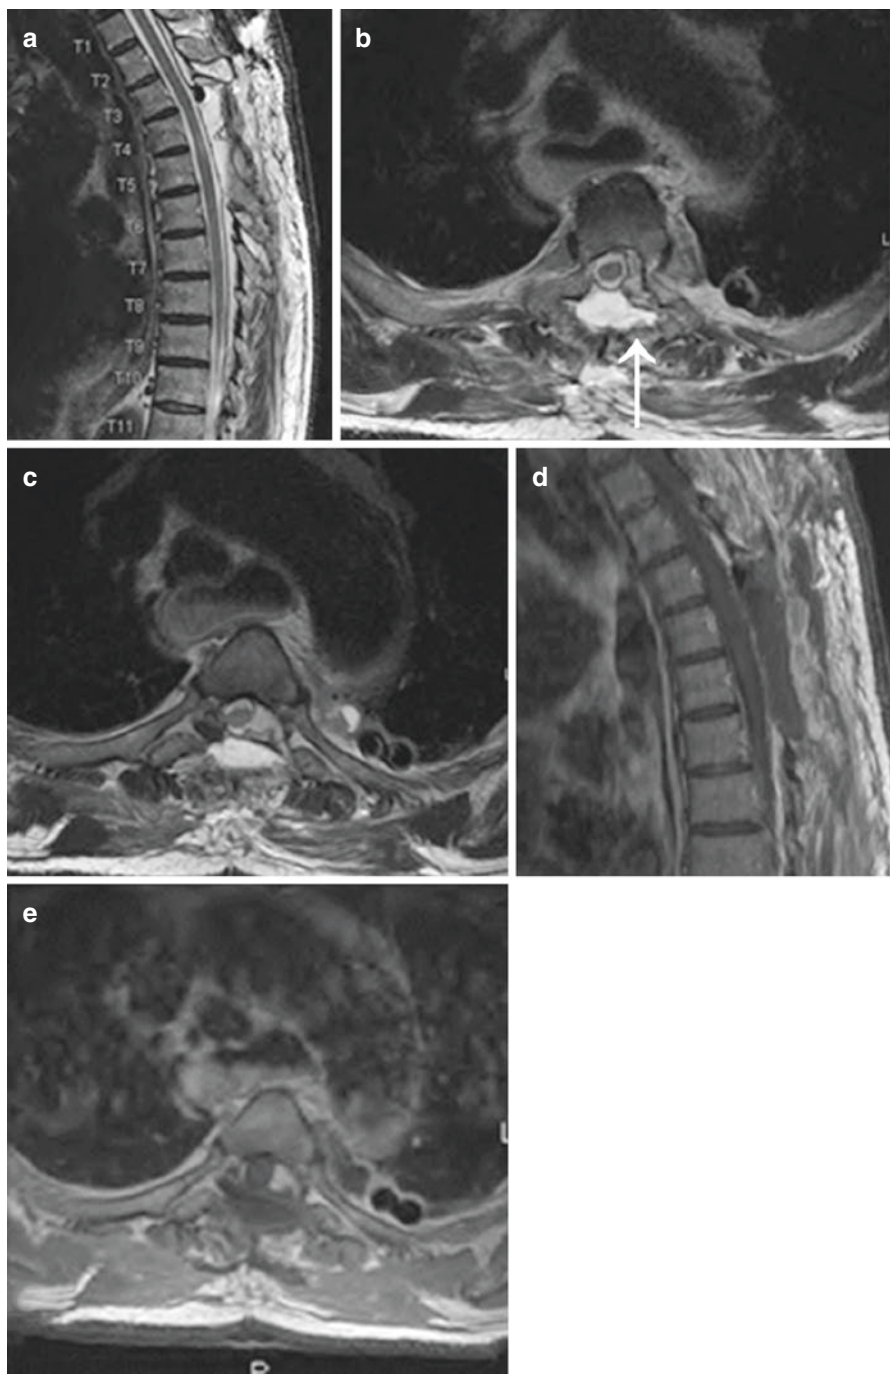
Imaging of a 78-year-old patient with progressive paraparesis and ataxia of the thoracic spine. (a) T2 weighted sagittal sequence showing the hyperintense intraspinal tumor T3–5; (b) postcontrast T1-weighted sagittal sequences showing homogenous enhancement of the tumor; (c, d, e) postcontrast T1-weighted axial sequences revealing dumbbell-shaped tumor extending intraspinally with displacement of the spinal cord to the right and growth through the intervertebral foramen of T4 into the left middle thorax. Note the lobular contour of the mass, which can be a clue to the diagnosis of hemangioma (arrows)
